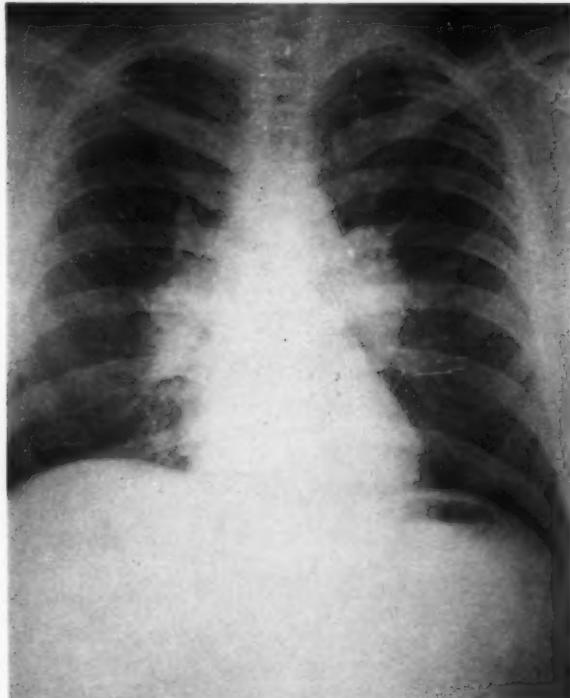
Roentgenogram of Case 3 showing bilateral hilar adenopathy which proved to be Boeck's sarcoid after biopsy.
